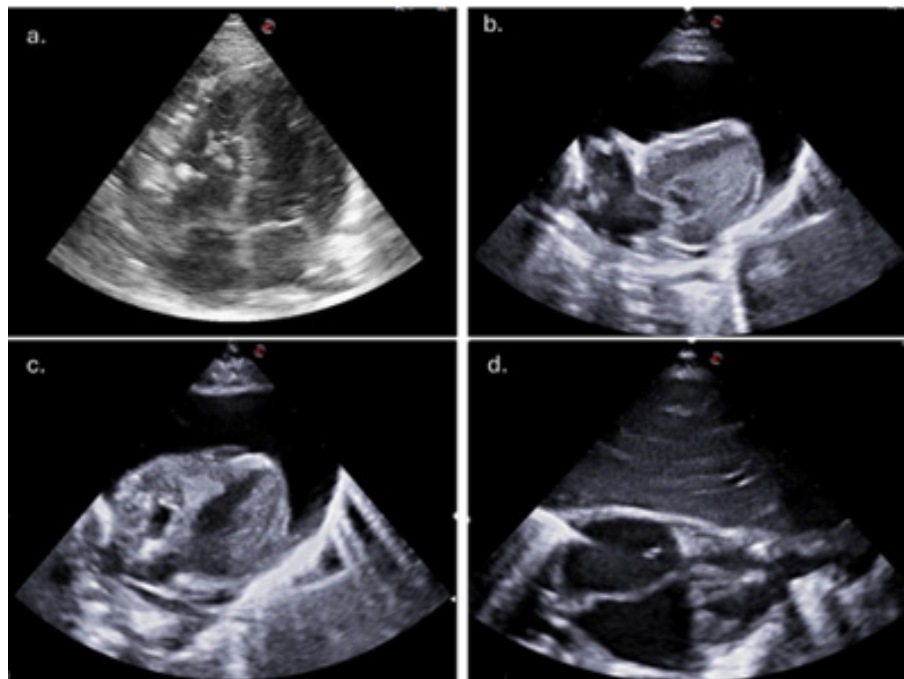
Echocardiography images before, during and after cardiac tamponade. (a) Four chamber view at arrival in newborn intensive care unit; (b) and (c) Images during cardiac tamponade with compression of the right ventricle free wall and “sickle effect” of left atrial roof (partial collapse during the whole cardiac cycle); (d) Subxyfoid view one hour after drainage positioning.
